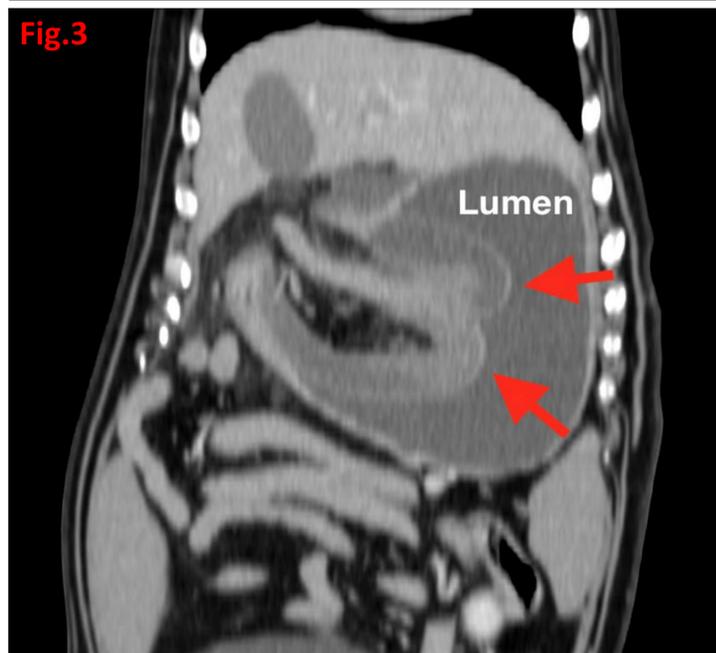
CT image in venous contrast phase and dorsal planar reconstruction with the intussusceptum highlighted by red arrows.
